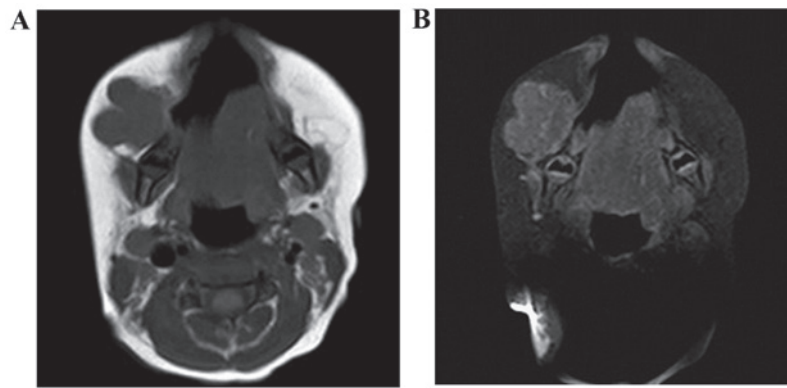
(A) Magnetic resonance imaging (MRI) axial T1-weighted (T1W) image showing a lobulated soft tissue lesion anterior to the right mandible. (B) MRI axial contrast-enhanced T1W image showing minimal enhancement.
